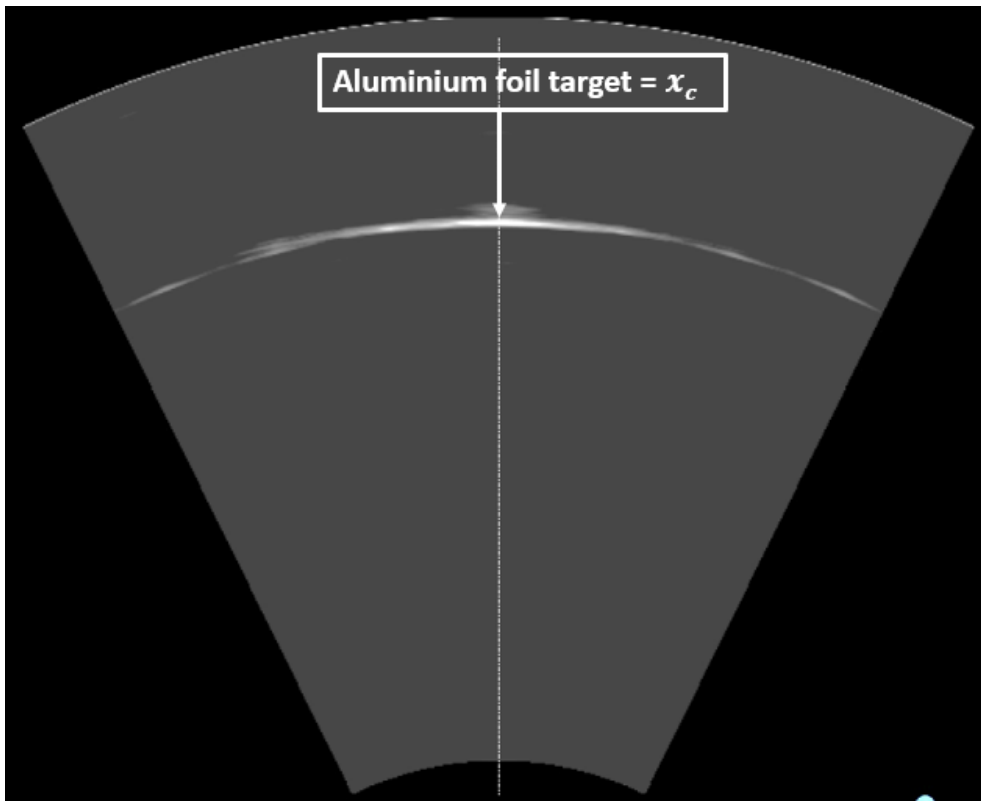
Ultrasound image within the optoacoustic setup showing the aluminium foil target, which serves as calibration position x_c . The ultrasound image was recorded at the same position as the optoacoustic measurement from which the calibration time was extracted. Figure adopted from Schauer et al. [86].
